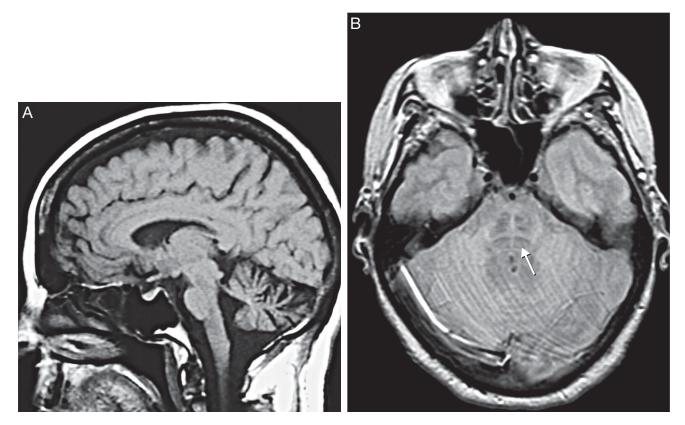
Magnetic Resonance Imaging of Multiple System Atrophy.
